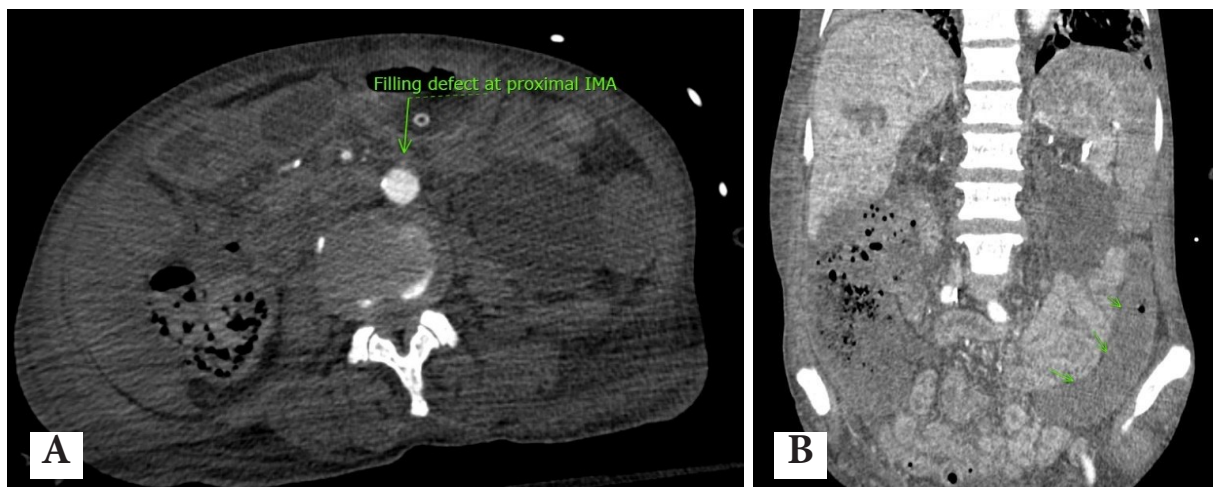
CT whole abdomen axial view (A) and coronal view (B), a 64-year-old female known case of COVID-19 infection with septic shock, abdominal pain and distension. CT imaging revealed a filling defect at the proximal IMA (A) and non-enhancement of the bowel wall of sigmoid and a descending colon (arrow), which typically indicate acute mesenteric ischemia (AMI) (B).
